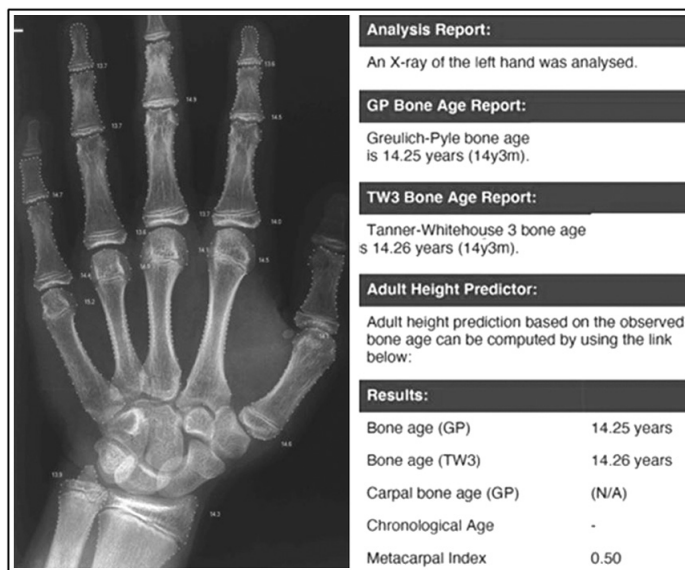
Bone age calculated from an X-ray of the patient's hand using BoneXpert software
